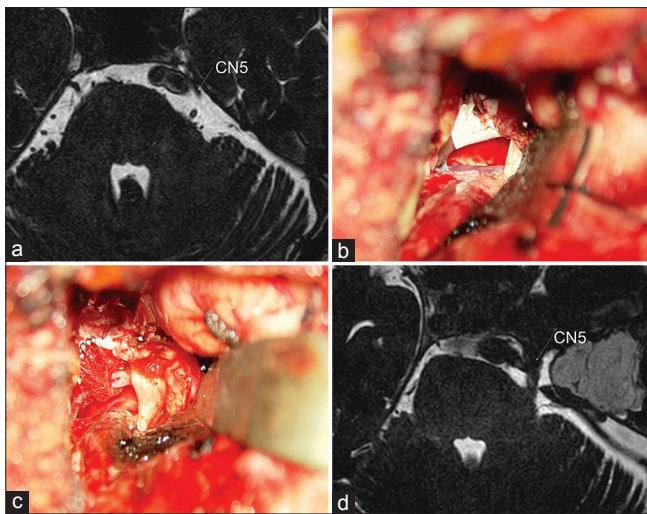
(a) Preoperative MRI FIESTA shows DVBA compressing the left CN5. (b) The DVBA was immobilized with GORE-TEX sling. (c) Left AICA was transpositioned with Teflon sling, and the Meckel's cave was opened to redirect the CN5. (d) The postoperative MRI scan confirmed the release of the nerve's compression and the straightening of the CN5. DVBA: Dolichoectatic basilar artery, FIESTA: Fast imaging employing steady-state acquisition, AICA: Anterior inferior cerebellar artery, CN5: Trigeminal nerve.
